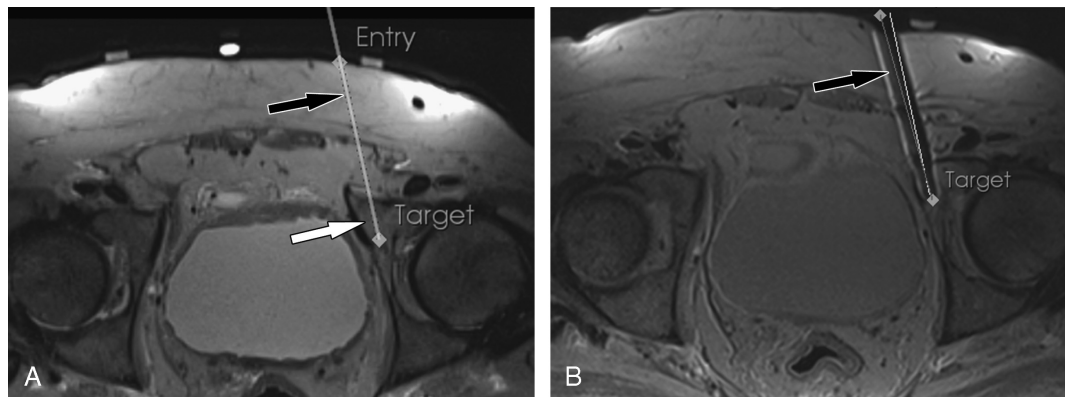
Image overlay navigated MR-guided biopsy of an osseous lesion of the left anterior acetabulum: A, Axial T2-weighted MRI demonstrates the planned biopsy path (black arrow) through an osseous lesion in the anterior aspect of the left acetabulum (white arrow). B, Axial intermediate-weighted turbo spin echo MR image after the drill placement demonstrates the tip of the drill (black arrow) through the target lesions. Postprocedural assessment of the target error using the PerkStation module of the 3D Slicer software shows the planned biopsy path (thick line) and the actual biopsy path (thin line). The target error was 3 mm.
